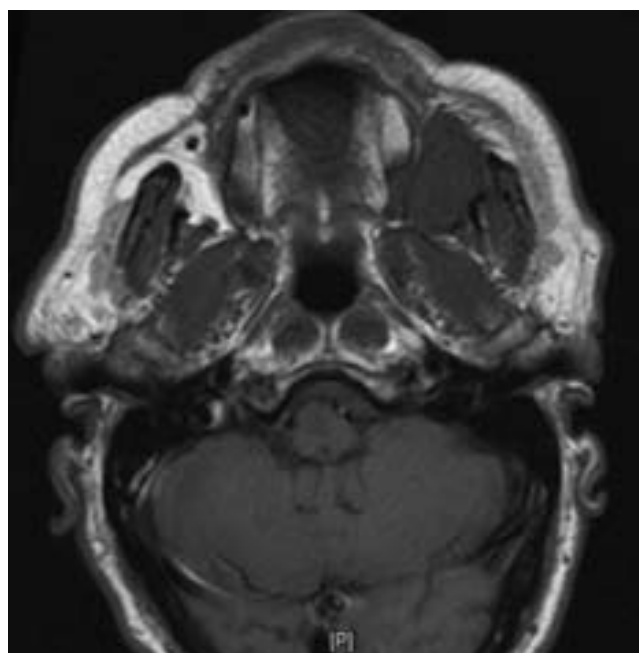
Solitary fibrous tumor: Magnetic resonance imaging showing mass of the left infratemporal fossa.
